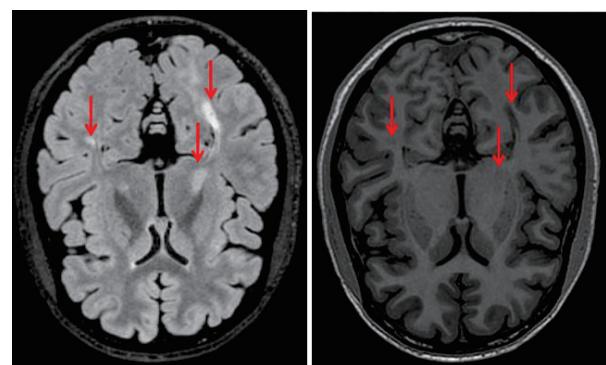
Difference between FLAIR (top) and T1 Images (bottom). Arrows indicate some WM lesion areas.
